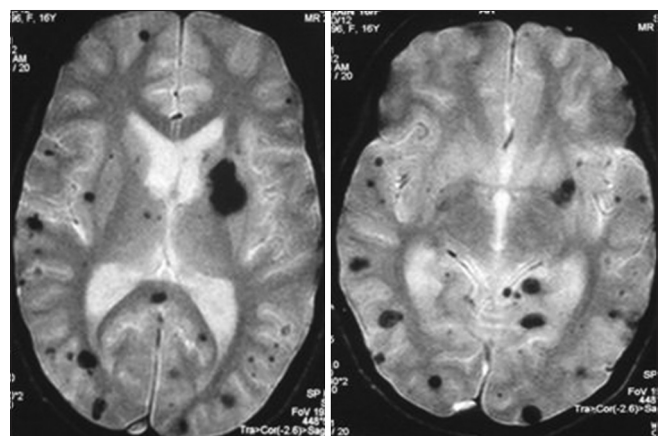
Follow-up GRE MR image, done after 72 h, shows multifocal areas of blooming within the lesions, suggestive of hemorrhage
